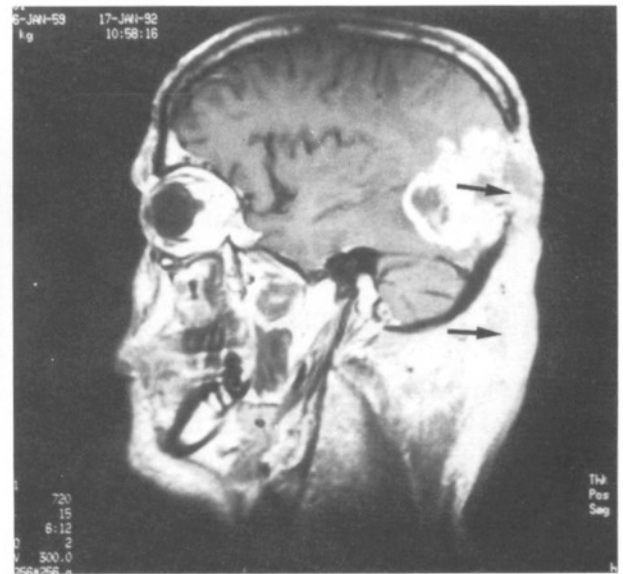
A,B : (A), T1 weighted coronal, and (B), sagittal MR images with Gd-DTPA showing a mass lesion with digital edema in the left parieto-occipital location. Invasion of the tumour through craniotomy defects to soft tissues in the left occipital and cervical region (small arrows). Lymphoma accumulation was observed in the tumour cavity after subtotal tumour resection in the cervical region (large arrow).
